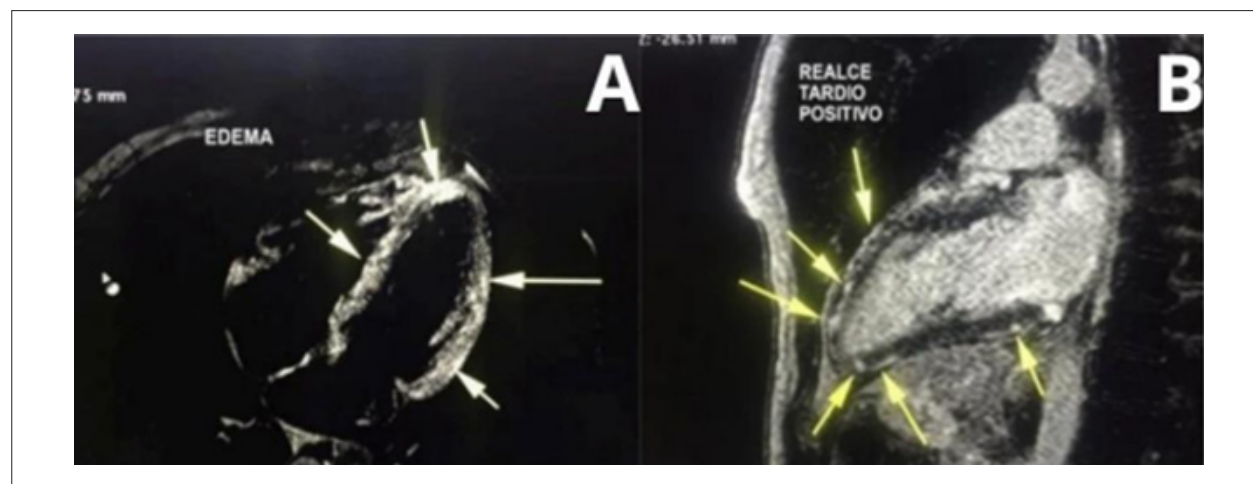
A) Triple IR T2-weighted T2 sequence in the four-chamber view demonstrating hyperintense areas suggestive of myocardial edema. B) Late gadolinium enhancement sequence in the two-chamber view demonstrating hyperintense areas with a mesoepicardial nonischemic pattern suggestive of myocardial fibrosis and/or necrosis. Source: Author's personal archive.
